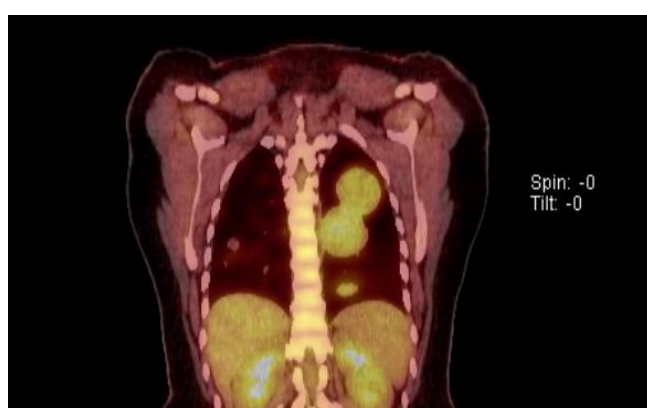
(left) PET-CT scan showing pulmonary nodules (PBML)
